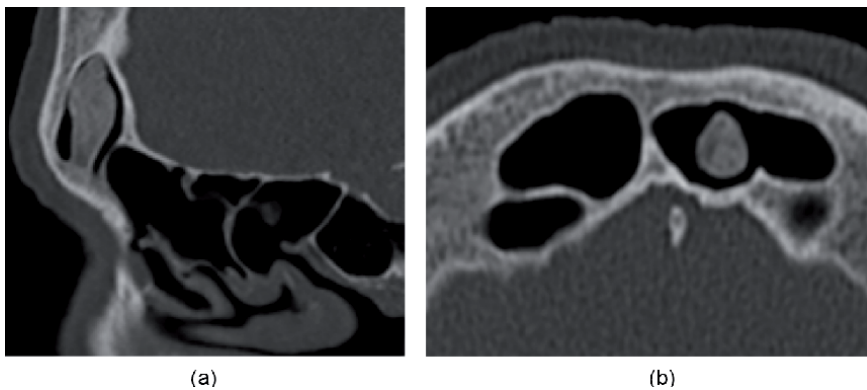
(a) Sagittal and (b) axial CT of an osteoma in the frontal sinus. Unless obstruction of the mucociliary drainage, osteomas have no clinical impact.
